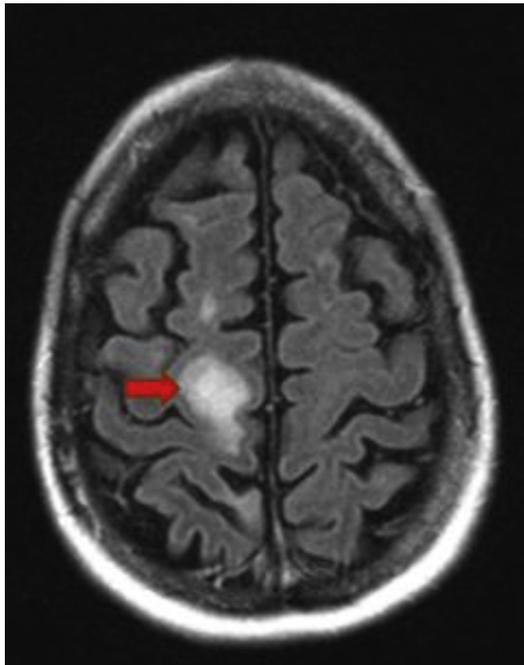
Axial FLAIR image demonstrates a large juxtacortical lesion (arrow).
